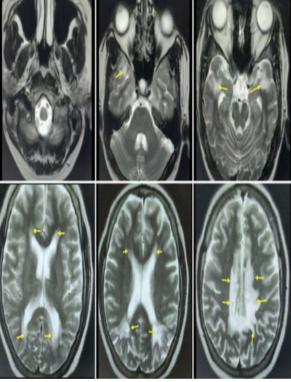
Axial T2-weighted MRI showing hyperintense signal in bilateral frontal, temporal, parieto-occipetal and periventricular white matter
